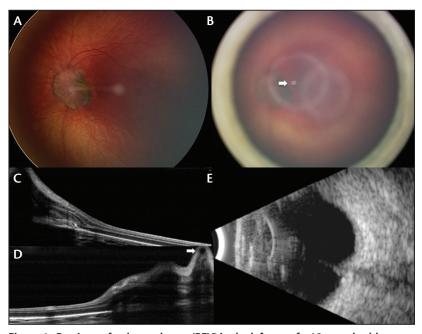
Persistent fetal vasculature (PFV) in the left eye of a 12-month-old female. Fundus image of the left eye showing fibrovascular stalk of persistent hyaloid artery toward the lens (A). The retina around the optic nerve was drawn up into the stalk, leading to a retinal pigment epithelial ring around the base. The disc was intact as seen through the dragged retina. Mittendorf dot from attachment of PFV to posterior lens capsule (B, white arrow). OCT horizontal cut through the optic nerve toward the foveola displaying retinal elevation and distortion (C). OCT vertical cut through the optic nerve displaying elevation of the fibrovascular stalk (white arrow) (D). Ultrasound showing fibrovascular stalk at disc region and thin hyaloid artery through the vitreous cavity (E).
